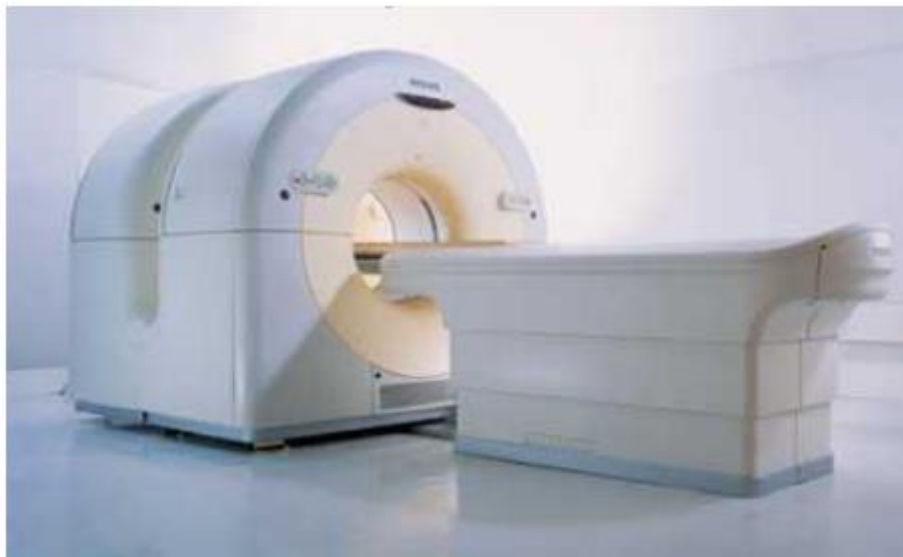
Images of CT PET scanner
